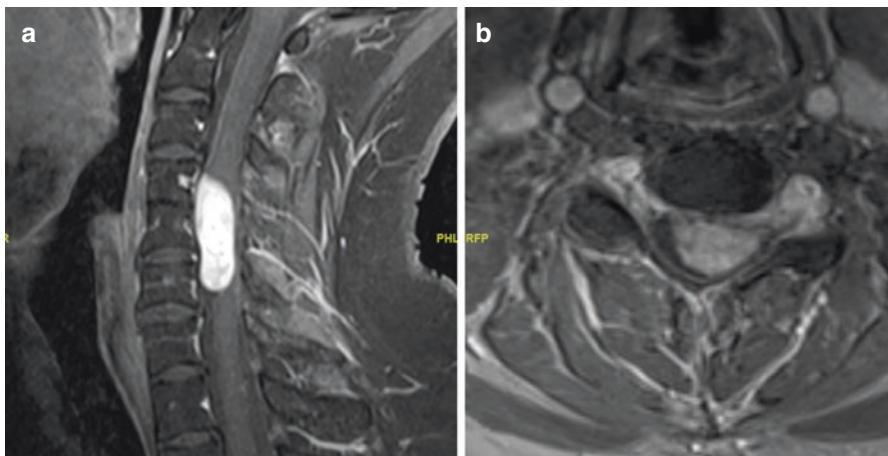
Cervical Spine MRI. Pre-operative Contrast-enhanced T1 sagittal (a) and axial (b) MRI images showing a large contrast enhanced tumor from C4–C6 with extension into the left C5 neural foramen, consistent with a nerve sheath tumor
